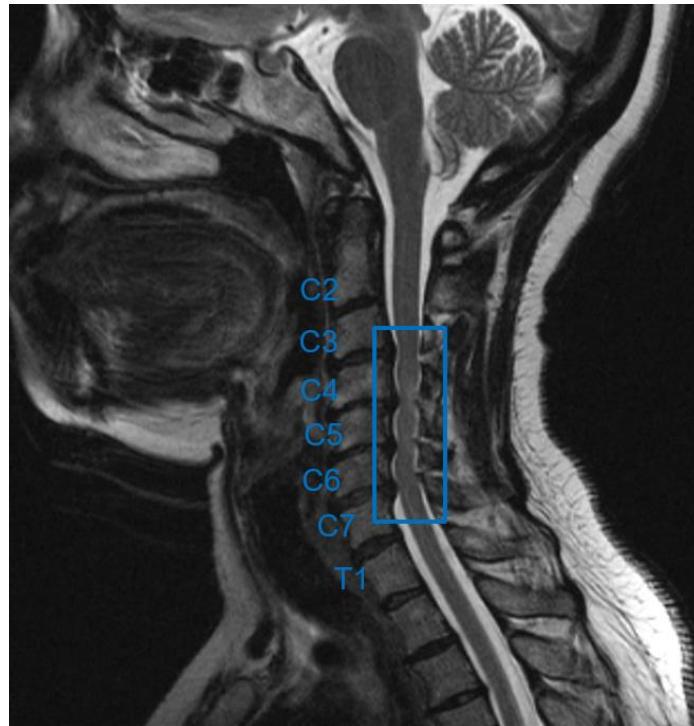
Sagittal T2-weighted MRI of patient with CSM. The different cervical levels are labeled, and the box denotes sites of compression from C3-C4 to C6-C7.
